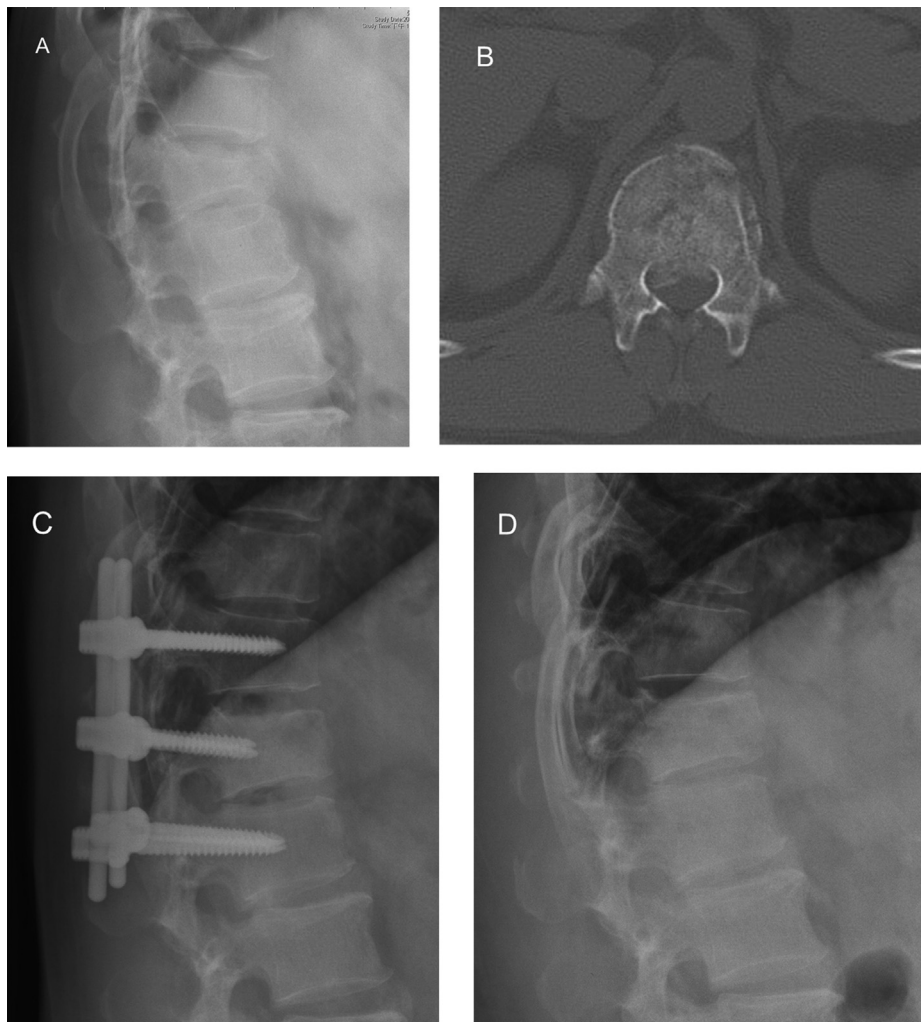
A 42-year-old male sustained L1 burst fracture in a motor vehicle accident. (A) Preoperative radiograph showed 27° local kyphosis and 49% anterior height collapse. (B) Preoperative axial computed tomography showed 52% canal encroachment. (C) Immediate postoperative radiograph revealed that the all-screws technique had corrected the deformity to 8° of local kyphosis and a 14% anterior body height collapse. (D) 18 months after surgery, the implants were removed and the radiograph showed the L1 body united. Local kyphosis deteriorated to 11° and anterior body height collapse increased to 17%.
